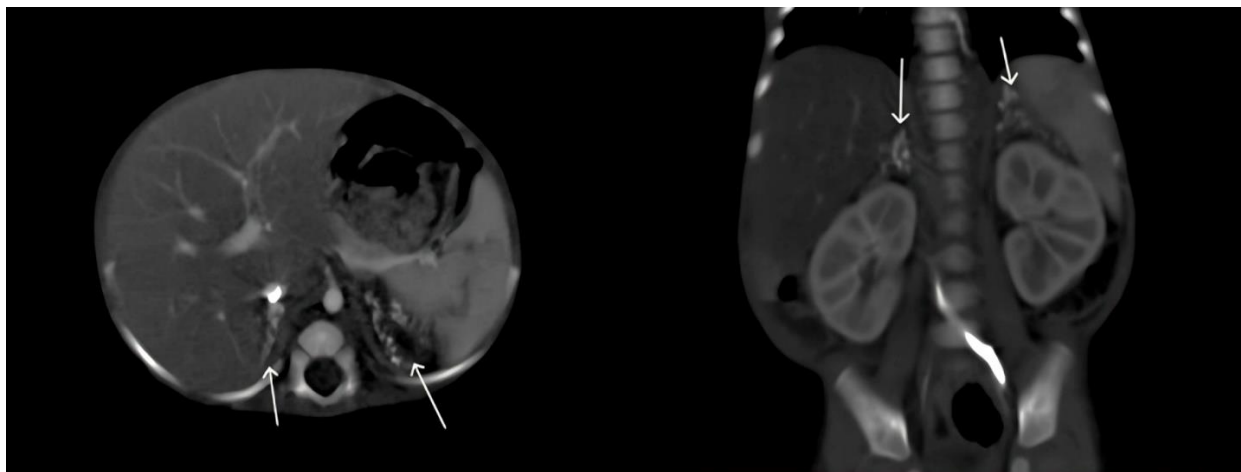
Coronal and axial contrast CT shows bilateral adrenal calcifications and hepatosplenomegaly.
